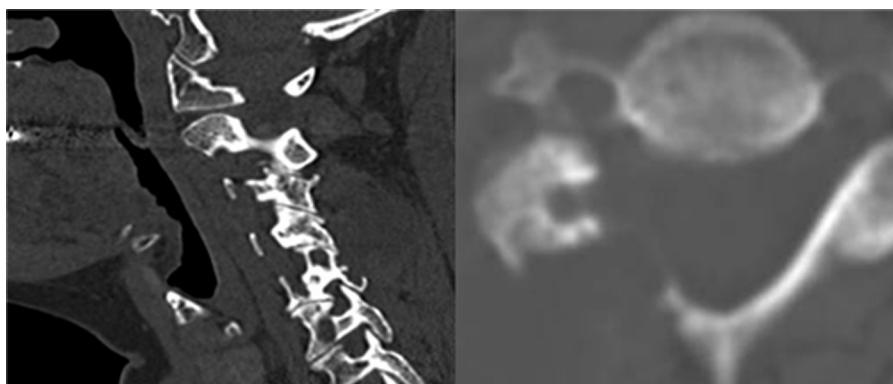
Computed tomography imaging (sagittal and axial views) reveals a lytic defect over the lamina of C5 and involving the right pedicle of C5.
